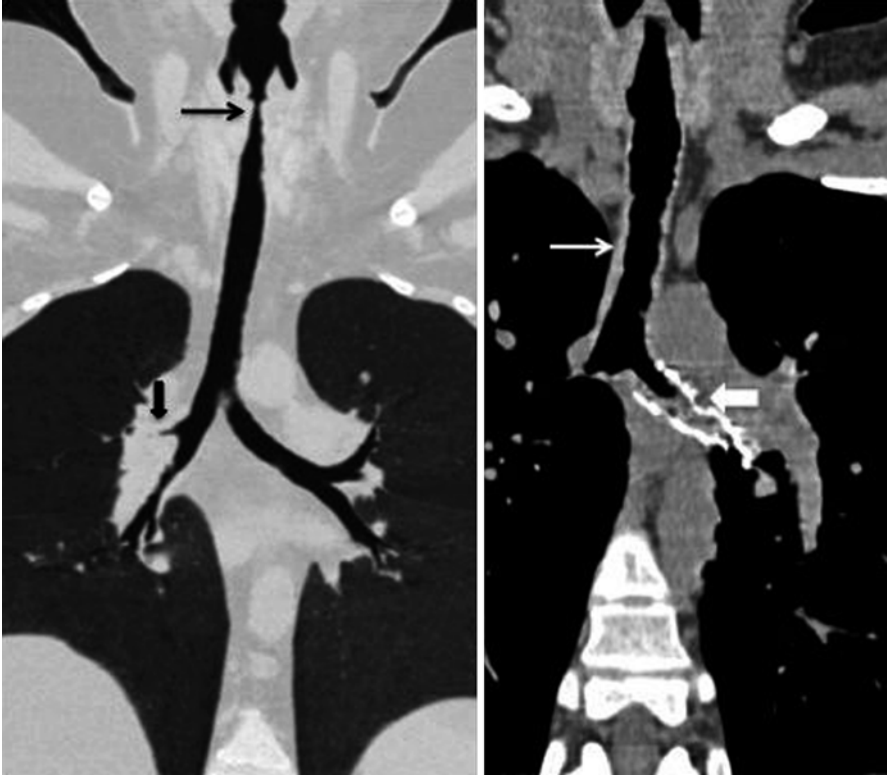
Coronal CT reformats in two different patients with Wegener's Granulomatosis and multifocal airways disease. *Left panel* shows high tracheal (*thin arrow*) and right segmental bronchial (*thick, black arrow*) stenoses. *Right panel* demonstrates tracheitis as evidenced by soft tissue thickening around the trachea (*thin arrow*) and re-stenosis of a left bronchial stent (*thick, white arrow*)
